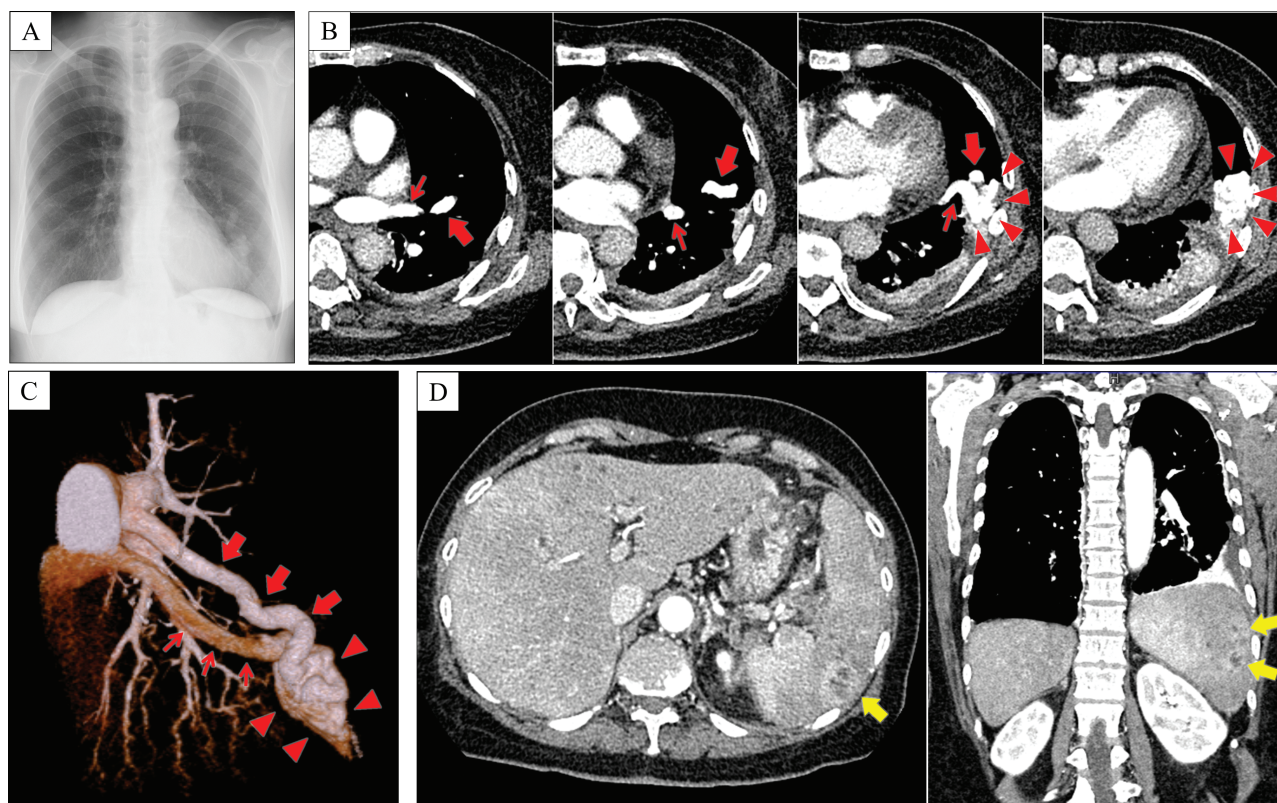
(A) Thoracic radiography showed an abnormal shadow suspected to be pulmonary arteriovenous malformation (PAVM) and associated artery and vein in the left lower lobe. (B, C) Enhanced computed tomography (CT) of the chest and three-dimensional CT showed PAVM sac (triangle), feeding artery (arrow), and draining vein (thin arrow). (D) Abdominal CT showed a heterogeneous low density area in the spleen (yellow arrow); this lesion was determined to represent splenic infarction and abscess.
